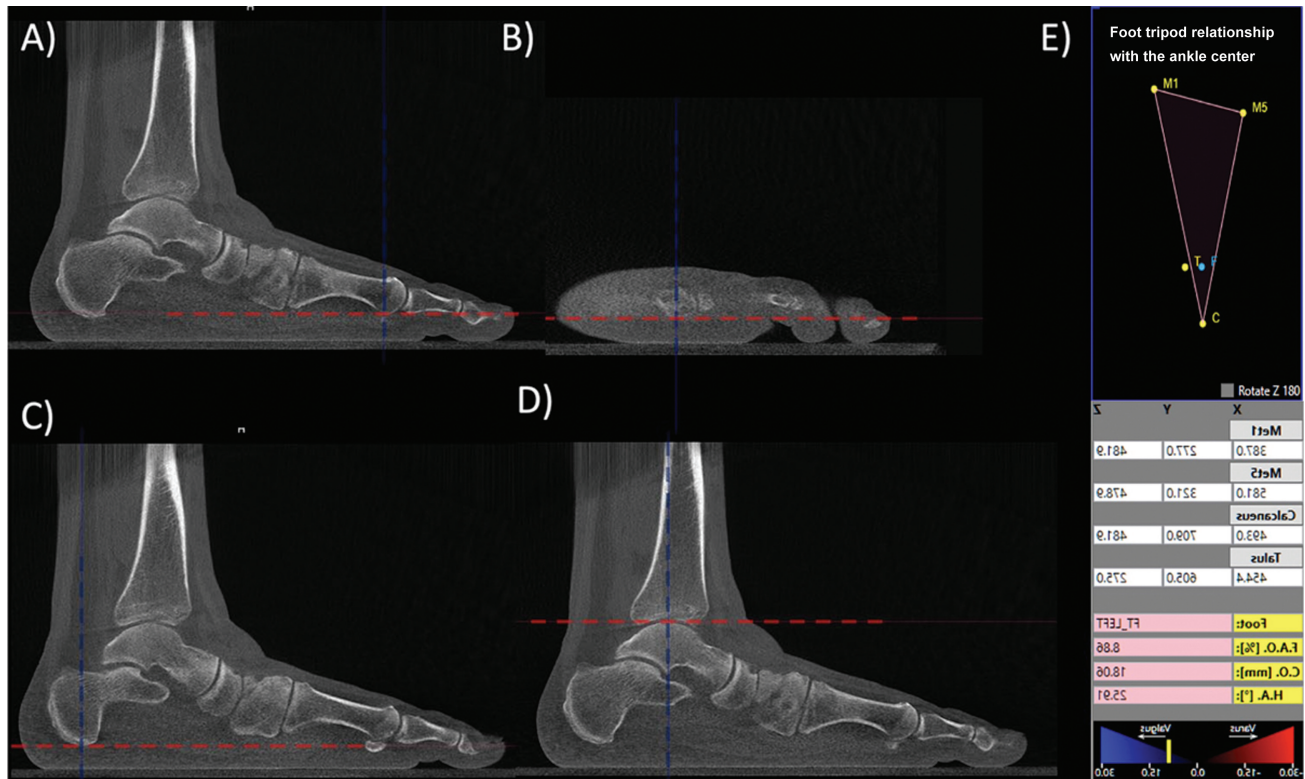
Three-dimensional coordinates to calculate the foot and ankle offset (FAO) weight-bearing computed tomography. (A) Sagittal section with marking at the lowest point of the head of the first metatarsal; (B) sagittal section with marking at the lowest point of the head of the fifth metatarsal; (C) axial section with marking at the lowest point of the calcaneal tuberosity; (D) sagittal section with marking at the highest point of the talar dome; and (E) example of a screen display of the software (CubeVue with the TALAS tool, CurveBeam AI, Hatfield, PA, United States) for semiautomatic calculation of the FAO displacement. We evaluated three-dimensional coordinates (x, y, z planes) of weight-bearing computed tomography images for the first (Met1, M1) and fifth (Met5, M5) metatarsals, the calcaneus (C), and the talus (T). These coordinates generated semiautomatic calculations of the foot tripod (triangle) and the ideal (F) and current actual (T) positions of the ankle joint center. In this example, the ankle joint center (T) is medial to the ideal ankle joint center (F), representing a valgus alignment of the hindfoot and an unbalanced tripod.
